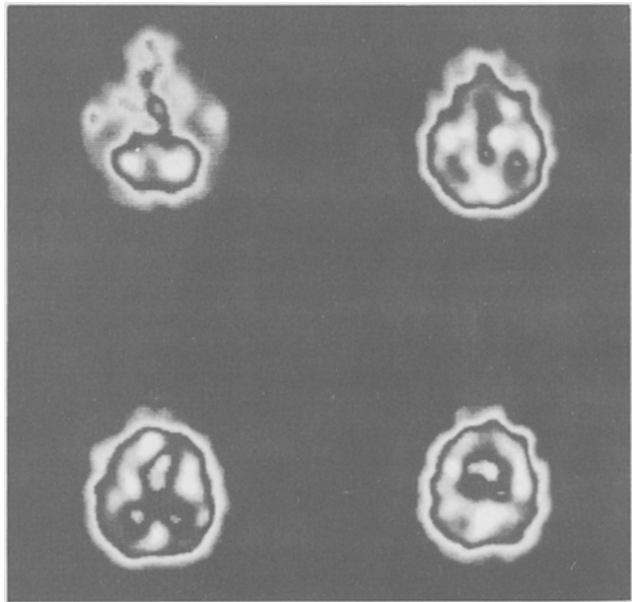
(b) — Case 1, follow-up SPECT study (1 month after stroke): no asymmetry of perfusion both at cerebellar and supratentorial level.
